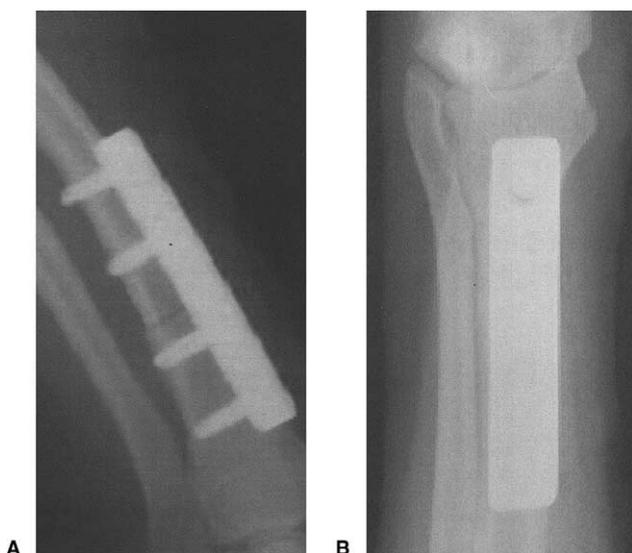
(A) Lateral postreduction radiograph. (B) Antero-posterior post reduction radiograph.
